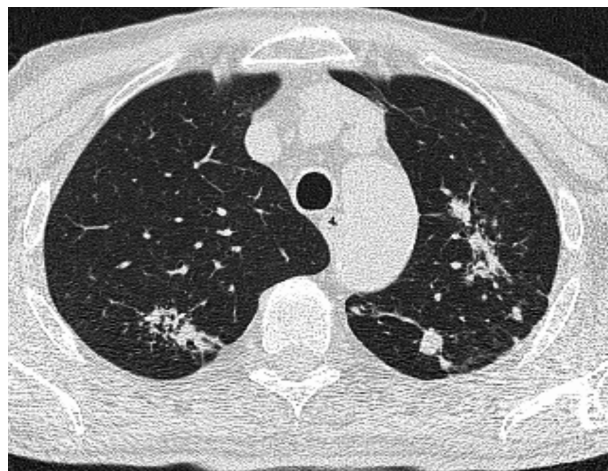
Computed tomography showing lesions in both lungs.
